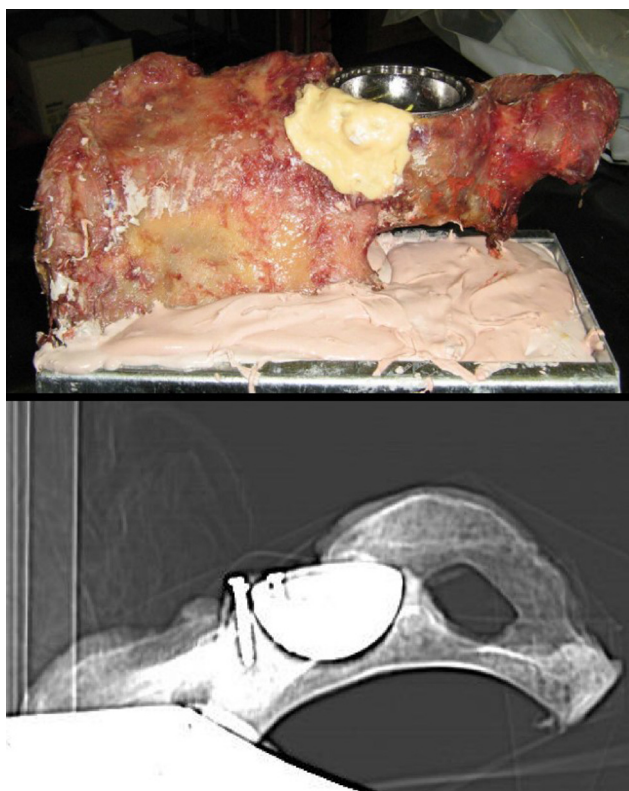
CT Scout image and actual picture of the implanted pelvis after acetabular augmentation.
